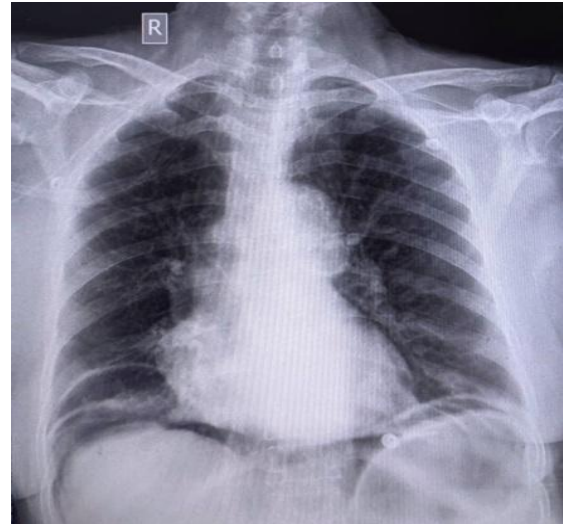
Chest X-ray before pigtail insertion
